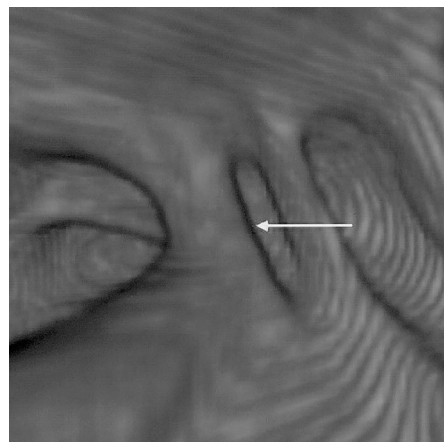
Differentiation of bulbous folds from polyps in 63-year-old man. (a) Transverse CT colonographic image shows a 7-mm pedunculated mass (arrow) suspected of being a polyp in the descending colon. (b) Coronal CT colonographic image shows that the lesion seen in a actually represents an interhastral fold (arrow) with a linear morphologic structure. (c) Three-dimensional endoluminal CT image findings confirm the linear morphologic structure (arrow) of the fold.
